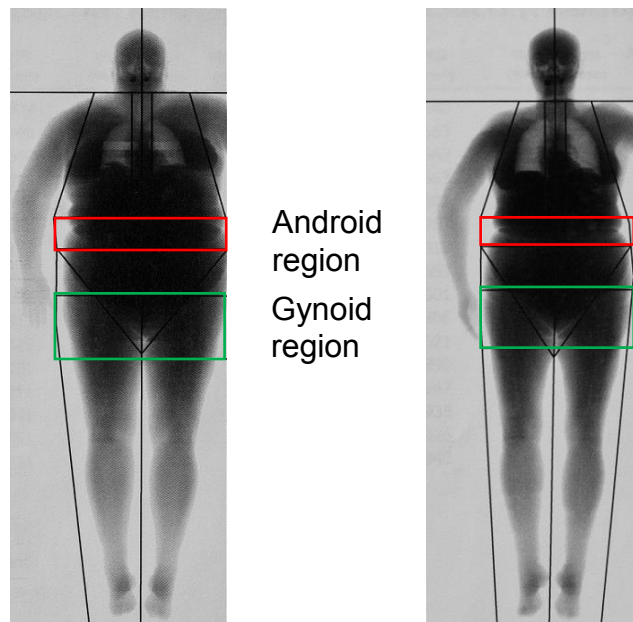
Dual-energy X-ray absorptiometry examination before (left) and after (right) Roux-en-Y gastric bypass. The android (red box) and gynoid region (green box) is indicated as defined by the software. Published with permission from the patient.
